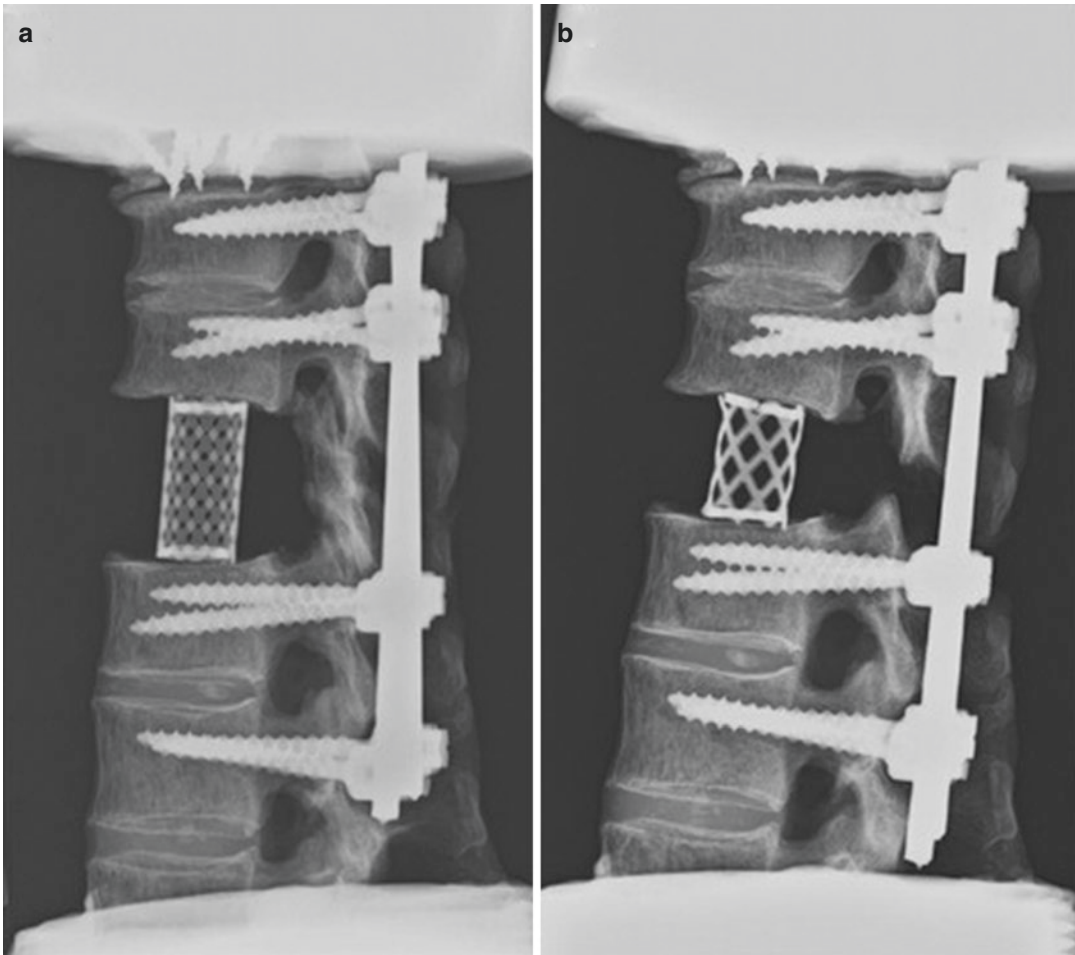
Lateral thoracolumbar radiographs of the two reconstruction models with different size cages: (a) 17 mm and (b) 10 mm. (Reproduced with no changes
